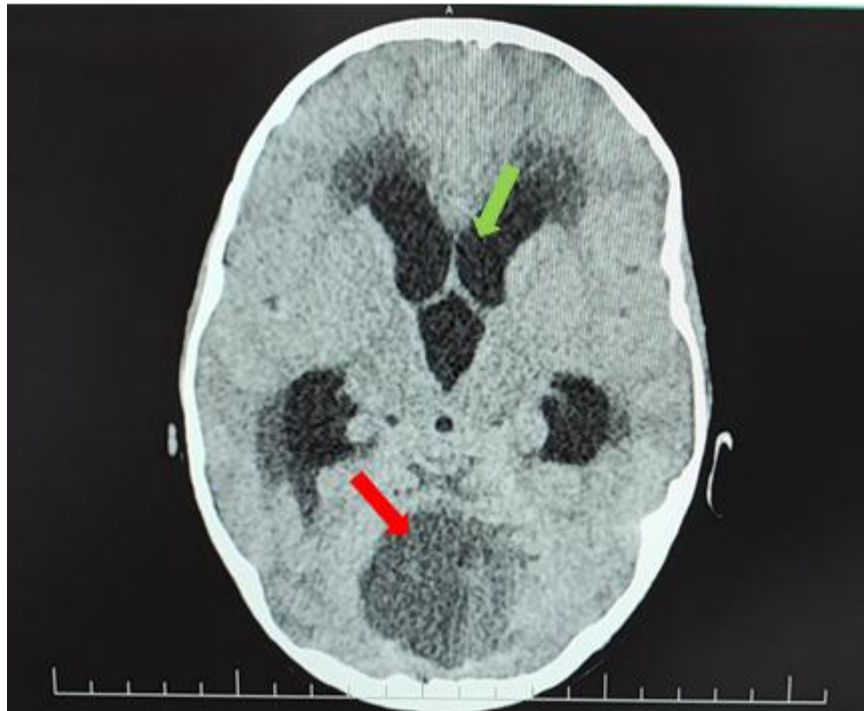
Non-contrast axial CT of the brain. The red arrow indicates tumoral expansion in the posterior fossa between the cerebellar hemispheres with pressure on the adjacent structures including the cerebellum and brainstem along with tonsillar herniation. The green arrow shows severe obstructive lateral ventricle hydrocephalus with signs of brain edema
